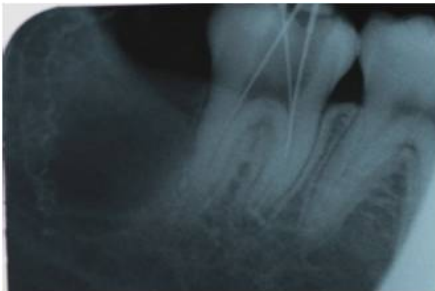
Intraoral periapical radiograph showing a large round radiolucency distal to the lower right second molar.
